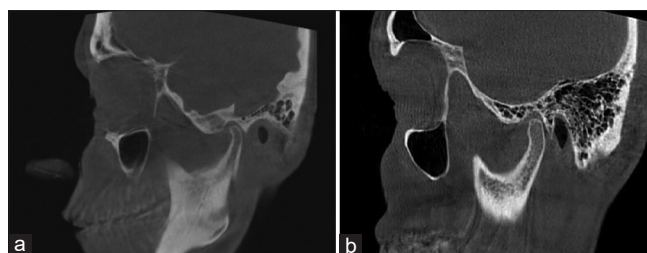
Sagittal CBCT images of pneumatized articular eminence. (a) Unilocular and (b) multilocular. CBCT: Cone-beam computed tomography.
